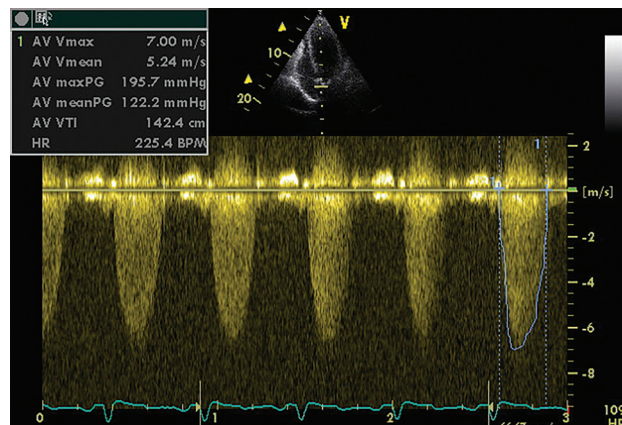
Continuous-wave Doppler signal of severe aortic stenosis jet shows high velocities.
